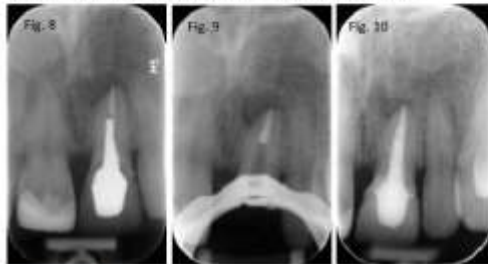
Radiographic examples of MTA within the canal system of an ULL. Fig. 8, Pre operative radiograph of a retreatment case. Fig. 9, Mid treatment radiograph with an MTA plug placed at the root apex. Fig. 10, Post operative radiograph following the placement of MTA & a fibre post with a temporary crown placed over the ULL.
